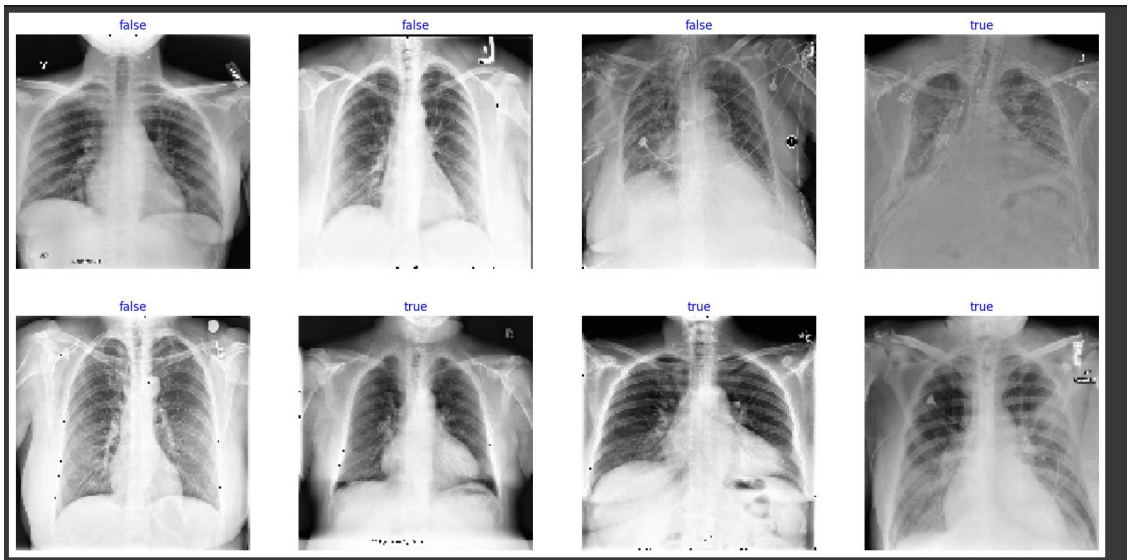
X-ray samples of the chest that were used for the classification task. Depending on the model's prediction result, each image is classified as either "true" or "false," showing both accurate and inaccurate classifications.
